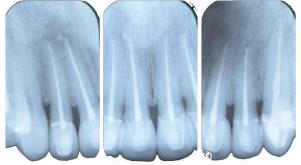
Postoperative picture and periapical radiograghs
